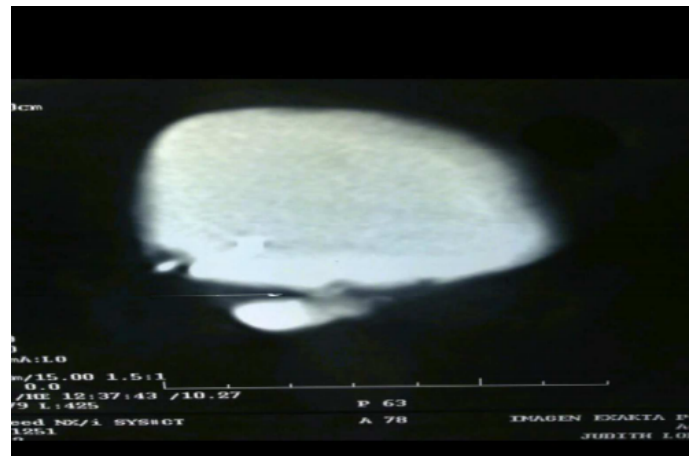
Cystography and CT scan showing the passing contrasted urine from the bladder to the vagina, diagnosis the vesico vaginal fistula in the posterior portion of the bladder near the vaginal dome
